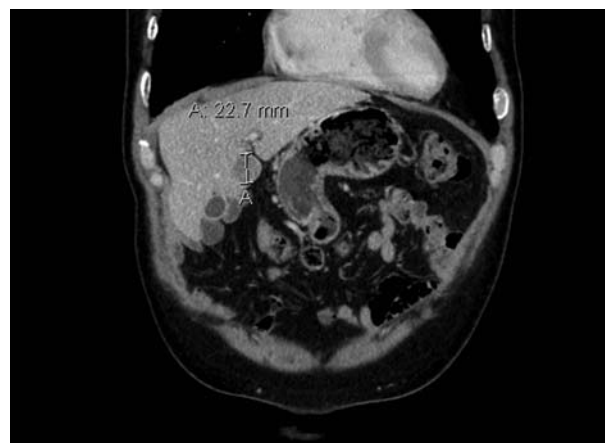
A small solitary liver metastasis detected on a CT scan in case 3.
